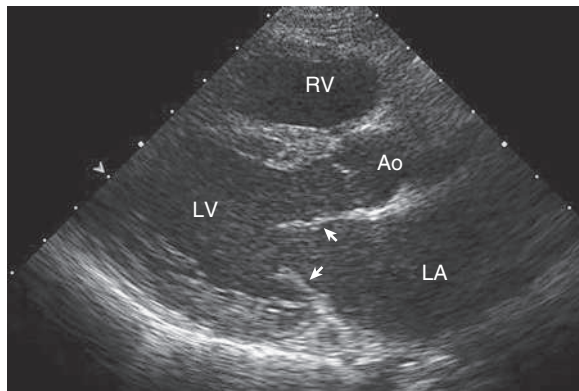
Normal parasternal long-axis echocardiographic window. The transducer is angulated slightly posteriorly, imaging the left-sided cardiac structures. If the transducer were to be angulated more anteriorly, the right ventricular structures would be imaged. The mitral valve leaflets can be seen in the partially open position in early diastole (arrows). The closed aortic valve leaflets can be seen just below the label Ao (aorta). LA, Left atrium; LV, left ventricle; RV, right ventricle.
